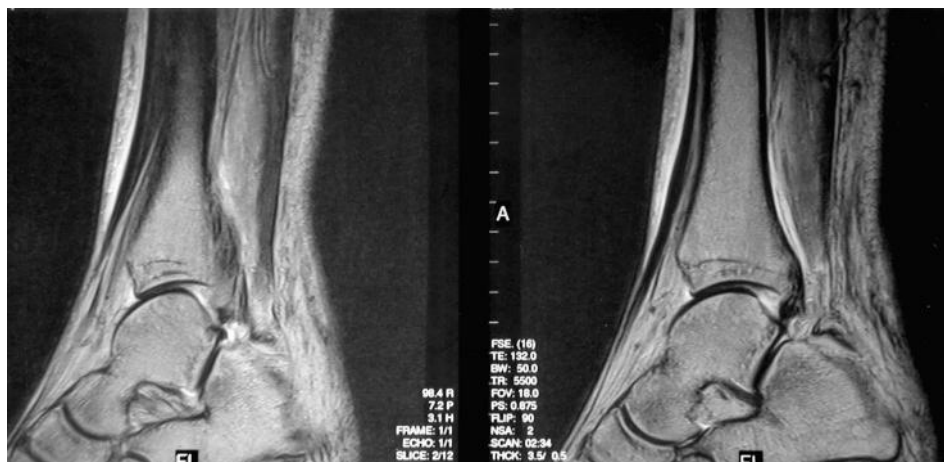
Postoperative MRI at 2 years demonstrating a viable tendon in perfect continuity with the recipient tissue.
